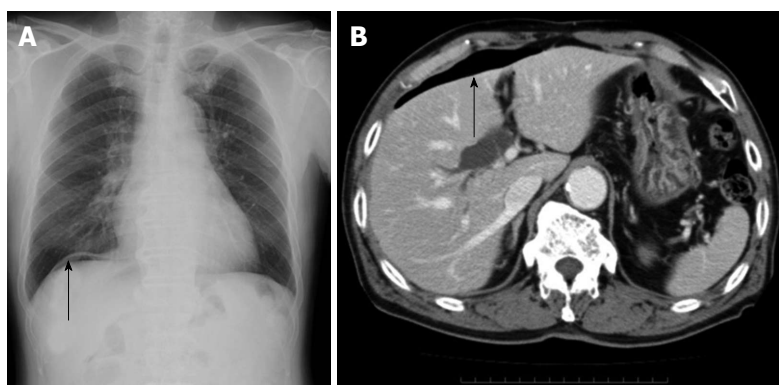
Radiography and abdominal computed tomography. A: A chest radiograph, showing free air below the right diaphragm (arrow); B: An abdominal computed tomography scan, showing free air (arrow).
